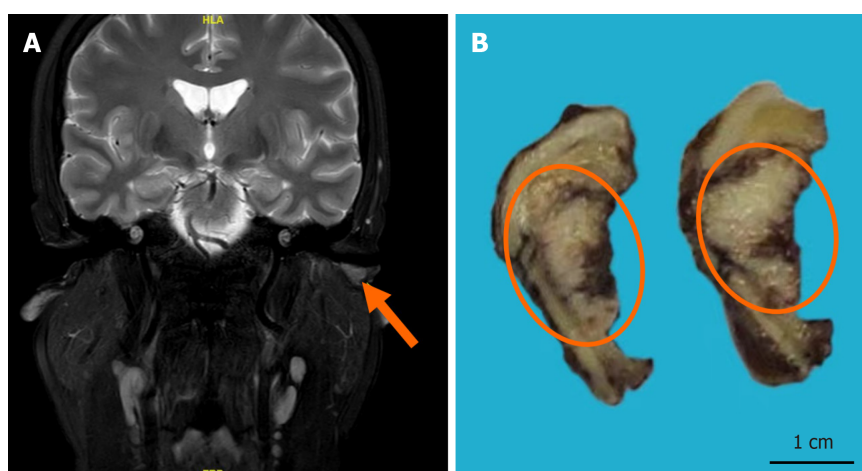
The magnetic resonance imaging and macroscopic view of the tumor. A: magnetic resonance enhanced scan of the inner ear canal showing a space-occupying lesion in the left external auditory canal (orange arrow); B: Macroscopic view of the tumor (orange circle).
